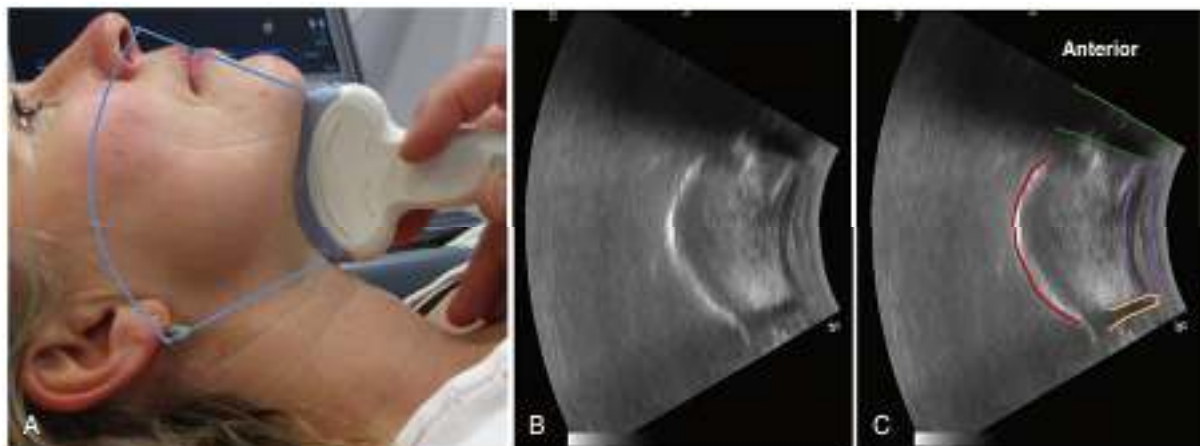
Longitudinal scan of the floor of the mouth and the tongue. (A) Placement of the curved low-frequency transducer. The area covered by the scan is outlined in light blue. (B) The resulting ultrasound image. (C) The shadow from the mentum of the mandible is outlined in green, the muscles in the floor of the mouth in purple, the shadow from the hyoid bone in yellow, and the dorsal surface of the tongue in red.
